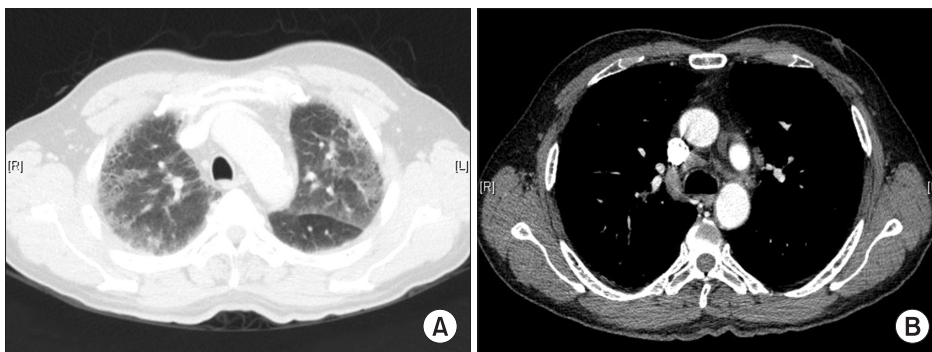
(A) Follow-up chest computed tomography (CT) in October 2012 shows the disappearance of the primary tumor in the subpleural area of the left upper lobe. (B) The same CT shows a marked decrease in the size of the multiple metastatic lymph nodes in the hilar, subcarinal, paratracheal, subaortic, prevascular and supraclavicular areas.
